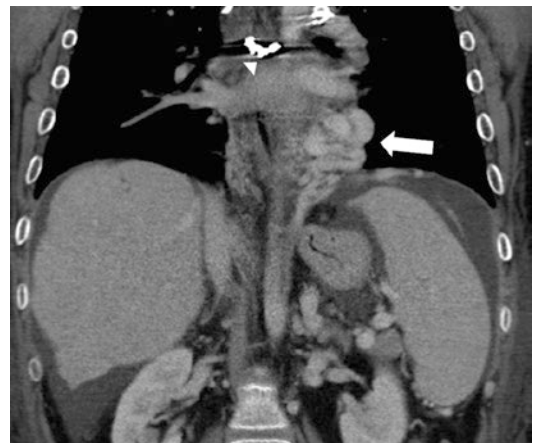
16-year-old male patient with cardiac cirrhosis, portal hypertension, and protein-losing enteropathy after Fontan procedure. Coronal abdominal CT images show morphologic changes of cirrhosis and portal hypertension with ascites and splenomegaly. Large systemic-pulmonary venovenous shunts (VVS) from the left suprahepatic vein to the left inferior pulmonary vein are also seen (arrow). Coils from prior embolization of VVS also noted in the mediastinum (arrowhead)
